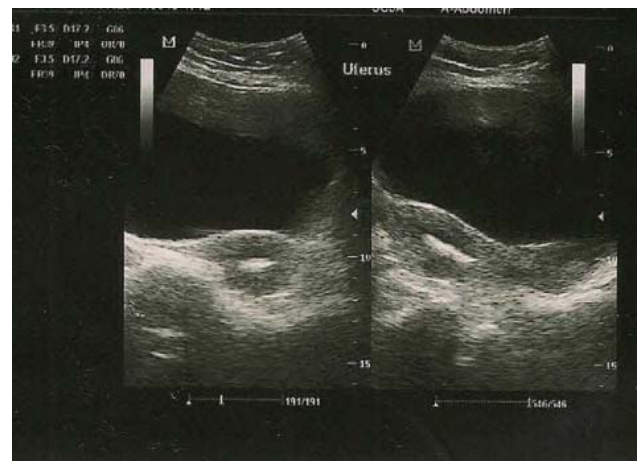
Ultrasound image showing hyperechoic area in the endometrium.
